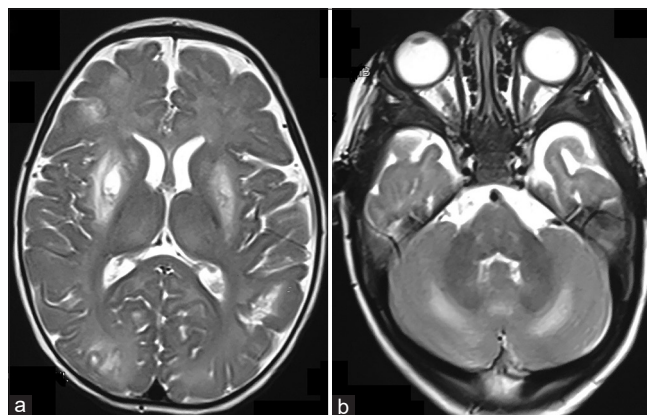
(a-b): Magnetic resonance imaging of the brain T2-weighted axial sections showing hyperintensities in bilateral caudate, putamen, cortical and subcortical white matter, with gliosis in the right putamen and left temporal lobe (B) bilateral involvement of the cerebellar hemispheres
